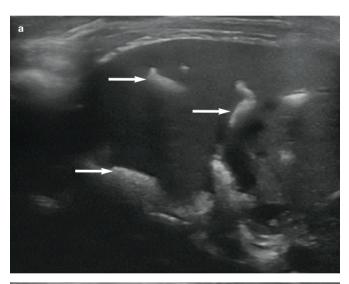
(a,b) Ultrasound images showing the typical appearance of echogenic sludge (arrows) within the gall bladder. The gall bladder wall is also thickened in (b)
